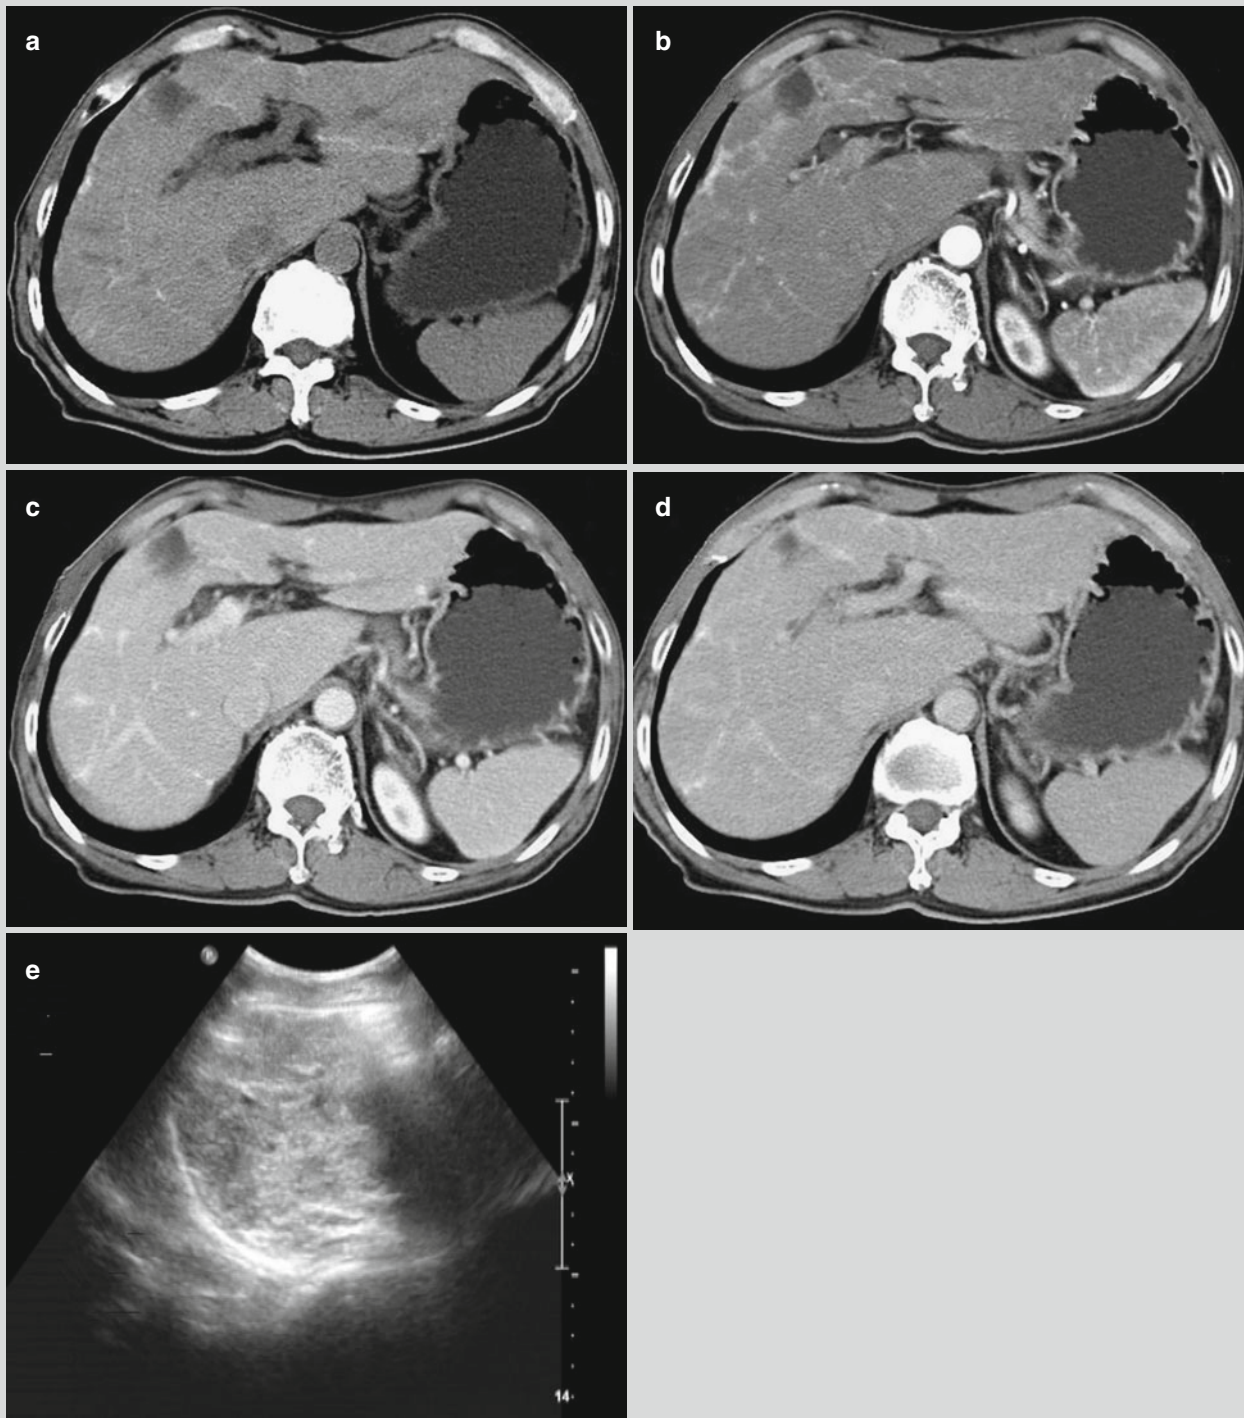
Hepatic schistosomiasis. (a) Plain CT scanning demonstrates deformed liver and flakes of low-density lesions in the right liver lobe with maplike calcification. (b–d) Contrast CT scanning demonstrates no enhancement of the lesions in the right liver lobe
